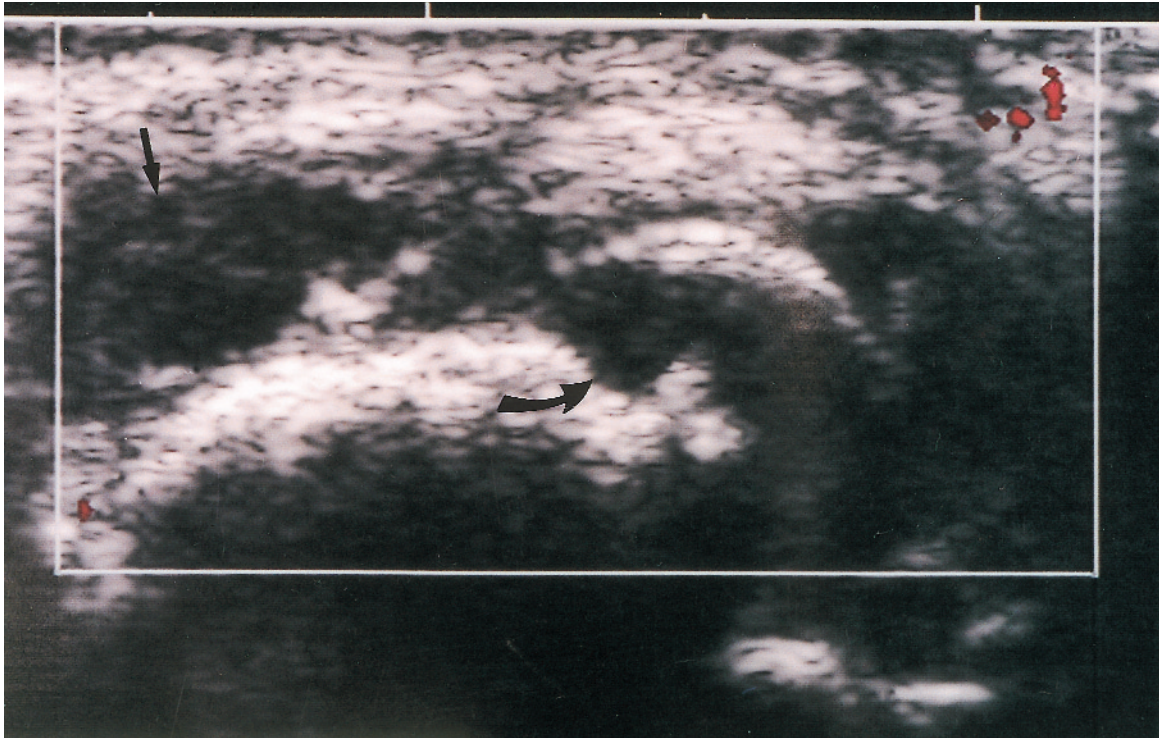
Followup transverse image of second metacarpophalangeal joint of the same patient 7 days after oral steroid treatment. Once again chronic changes of rheumatoid disease are seen; thickened irregular synovium (straight arrow) and large erosion (curved arrow). With power Doppler there is no evidence of active synovitis; power Doppler grade 0.
